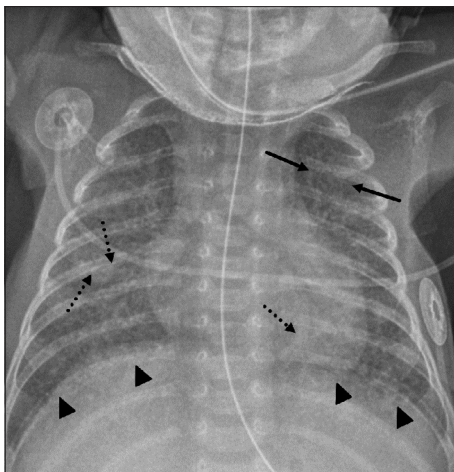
Chest radiograph of a 150-day-old female infant born at 32 weeks' gestation shows interstitial coarse thickening (black arrows), overinflation (black arrowheads), and bands of atelectasis (dashed black arrows), compatible with fibrosis in the setting of chronic lung disease of prematurity
